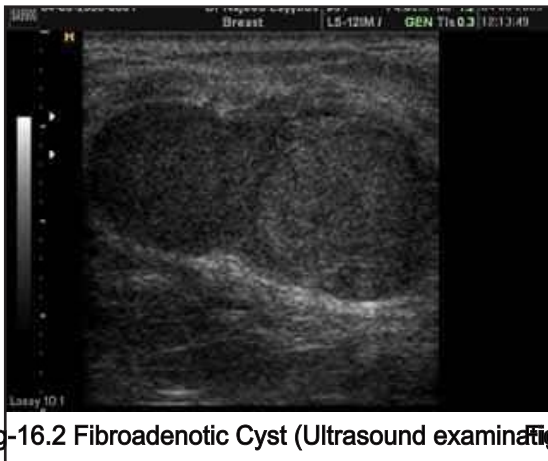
Fibroadenotic Cyst (Ultrasound examination)
